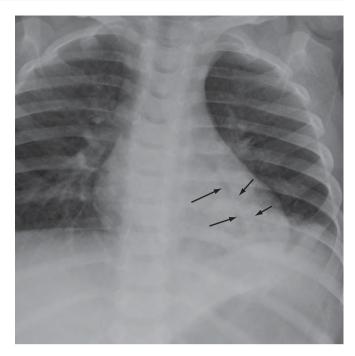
Bronchogram sign. Frontal radiograph in a 21-month-old boy with cough and fever demonstrates an irregular increased density in the left lower lobe. Air-filled bronchi are seen (*arrows*) because they are surrounded by nonaerated lung.
